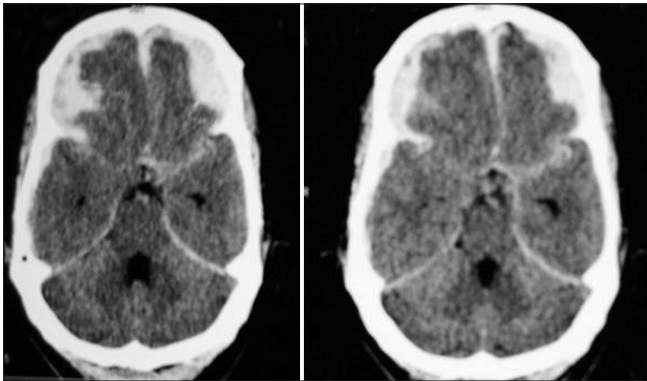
Axial computed tomography done on the day of ictus showing bilateral subdural hematoma with interhemispheric extension and diffuse subarachnoid hemorrhage
